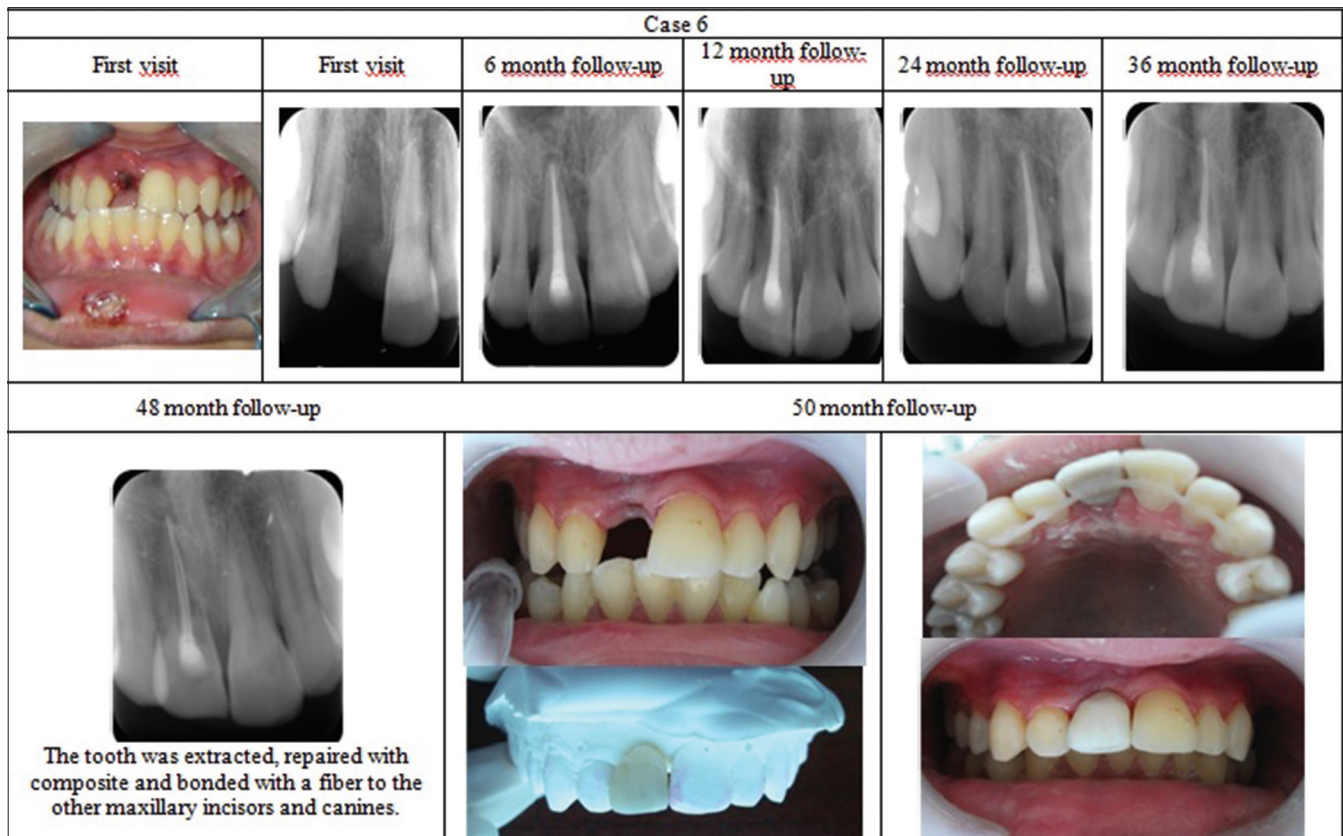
Radiographic and clinical records of case 6
